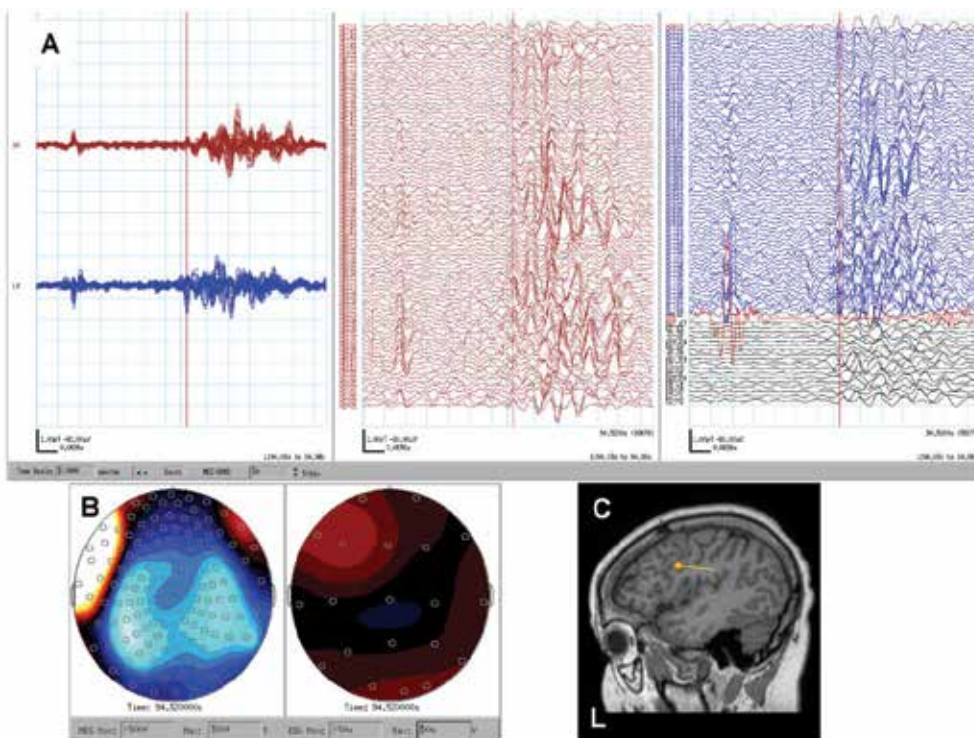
The earliest component with a reasonable magnetic field topography of generalized polyspike-burst. A, The earliest component with a reasonable magnetic field topography of a polyspike-burst is selected (red cursor). B, Magnetic field topography shows bilateral “sink and source” pattern with left hemispheric predominance. C, Single moving dipole analysis shows an MEG dipole in the left middle frontal gyrus on sagittal MRI.
